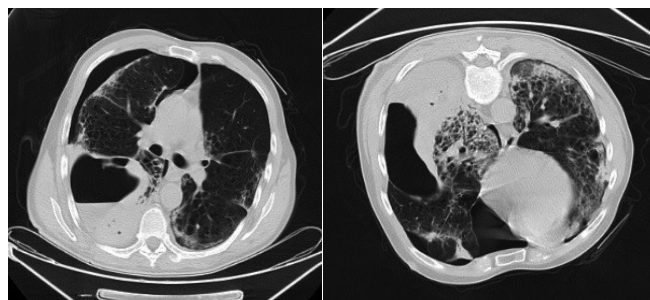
On day 20th, computed tomography scans show bilateral consolidation, honeycomb, and right hydropneumothorax
